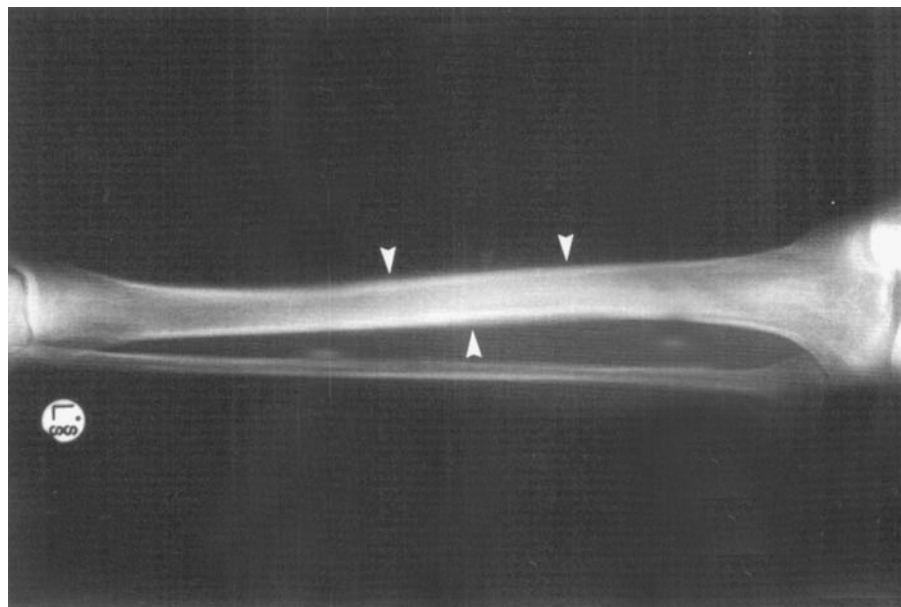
Plain x-ray of symptomatic left leg demonstrating subperiosteal new bone formation along shaft of tibia (arrow heads), typical of hypertrophic pulmonary osteoarthropathy.
